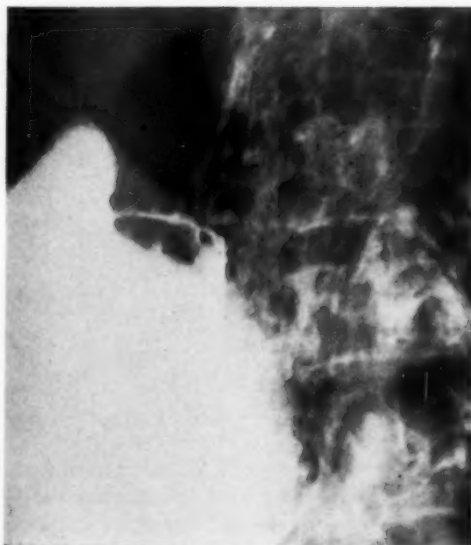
Roentgenogram made seven months after that in Fig. 1. The appearance of the duodenum is unchanged.
